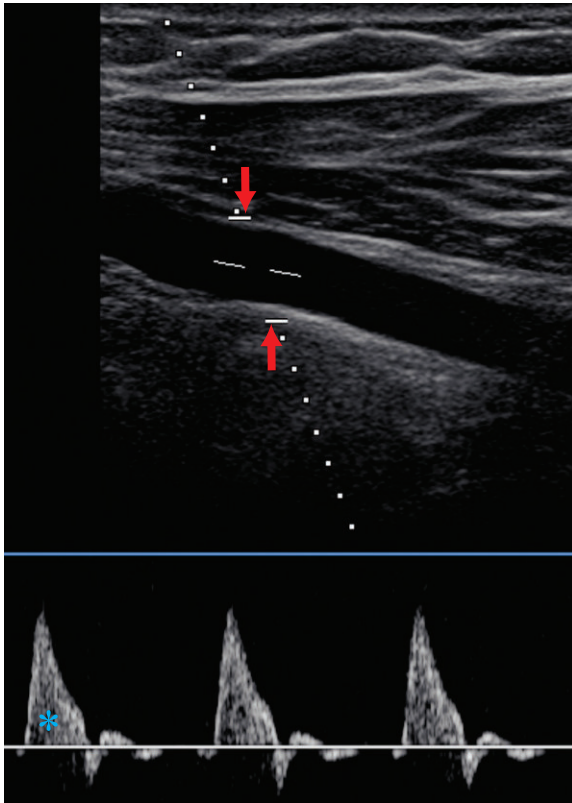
Spectral Doppler of the subclavian carotid artery demonstrates spectral broadening due to an overly large sample volume (between arrows). There is filling in of the window (*). The artery has plug flow but the lower velocities at the wall are now detected because the sample volume includes the blood flowing near the vessel wall. Sample volume sizes are generally not larger than half of the vessel diameter.
